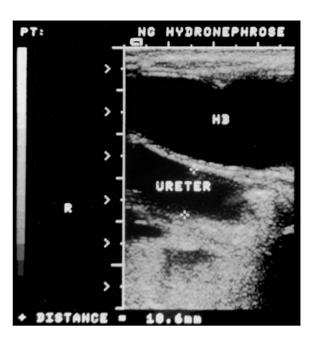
Ultrasonographic demonstration of a large bladder (HB) with thin bladder wall and a dilated ureter in a newborn infant with prune belly syndrome
